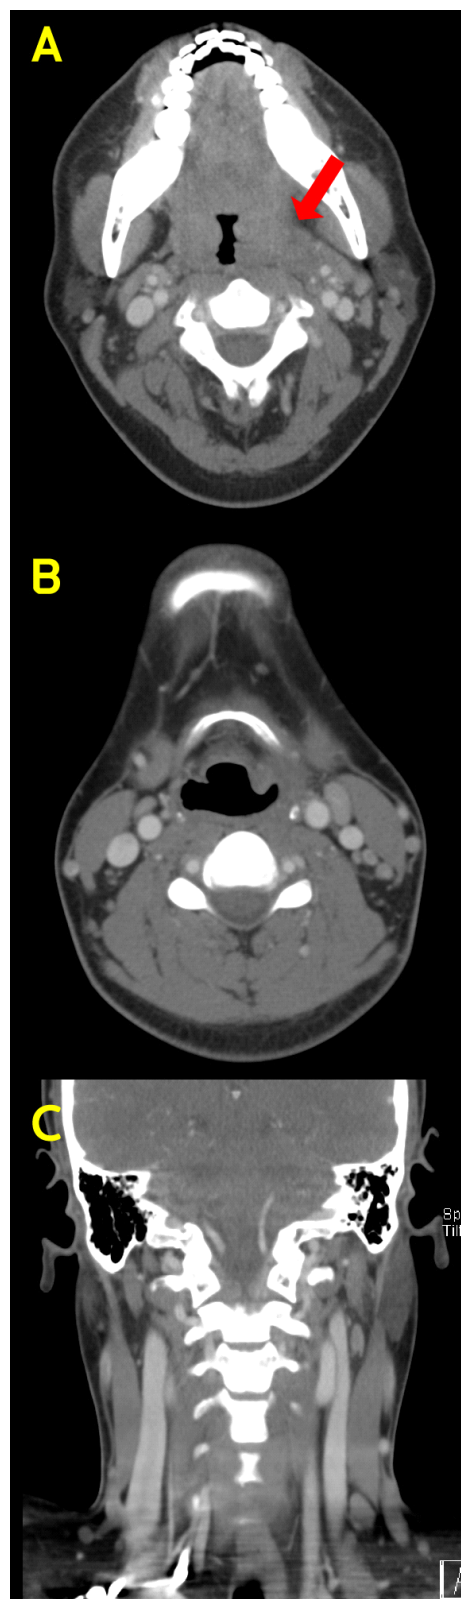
Computed tomography of neck. It shows diffuse enlargement of both tonsil (A) and reactive lymph nodes in both neck level II, III. (B) There is no definite evidence of internal jugular thrombophlebitis. (C)
